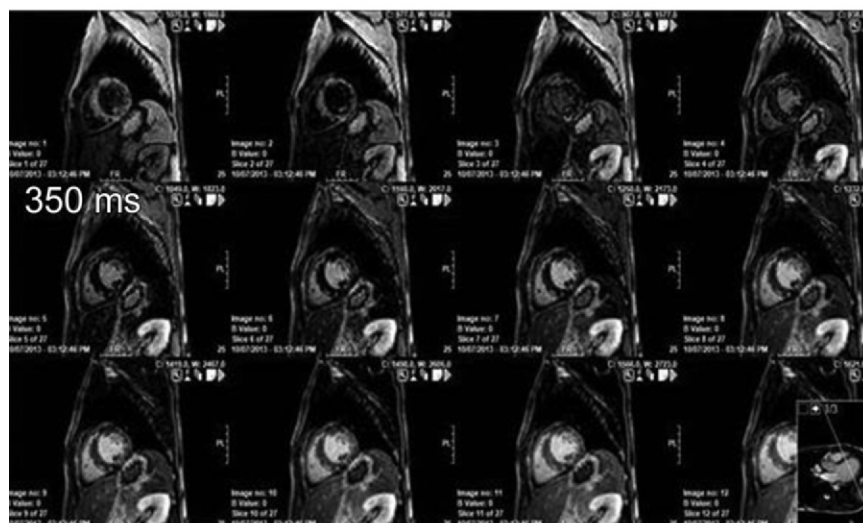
Inversion times at 1.5-T and 3-T MR imaging. (a) T1-weighted scout map obtained 10 minutes after contrast agent administration (0.2 mmol/kg) shows myocardial signal intensity at various inversion times at 1.5 T. The optimal myocardial nulling time for this sequence is 260 msec. (b) T1-weighted scout map obtained at 3 T demonstrates that the optimal myocardial nulling time is 350 msec. The myocardial nulling time is longer at 3 T because of the longer T1 of myocardium.
